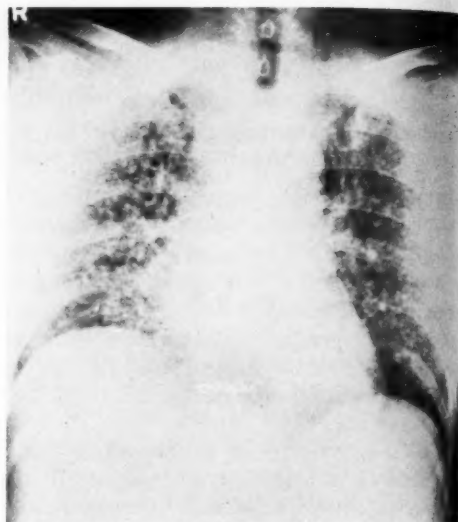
Admission chest film showing bilateral hematogenous ("miliary") dissemination of *Salmonella septi-cemia*. The magnification of the parenchymal lesions was due to the fact that the radiograph was taken in the supine position at 36 in. T.F.D.
